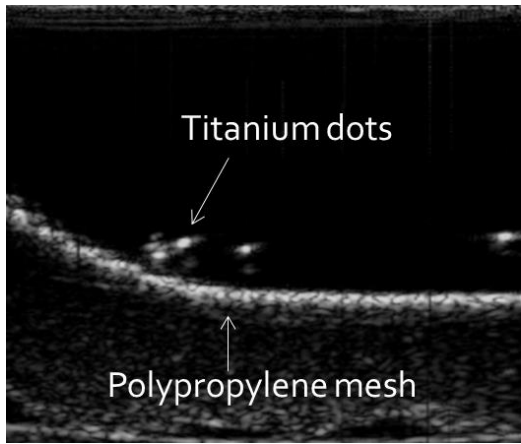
Ultrasound Image of Titanium Wire and Polypropylene Mesh
